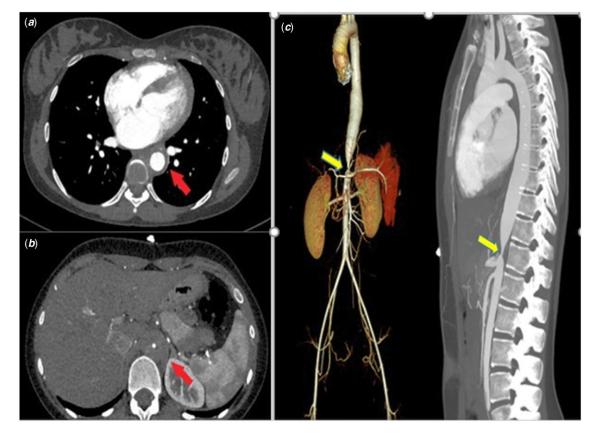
CT angiography shows *a*) that there was diffuse increase in the wall thickness (red arrow) in the descending aorta, the aortic wall was concentrically thickened. *b*) Aortic wall thickening progressively increased and the diameter of the thoracic aorta decreased abruptly (red arrow) at the level of the diaphragmatic hiatus up to coeliac trunk in axial slices. *c*) There is abrupt decrease (yellow arrow) in aorta up to coeliac trunk in 3D surface shaded image and MIP image.
